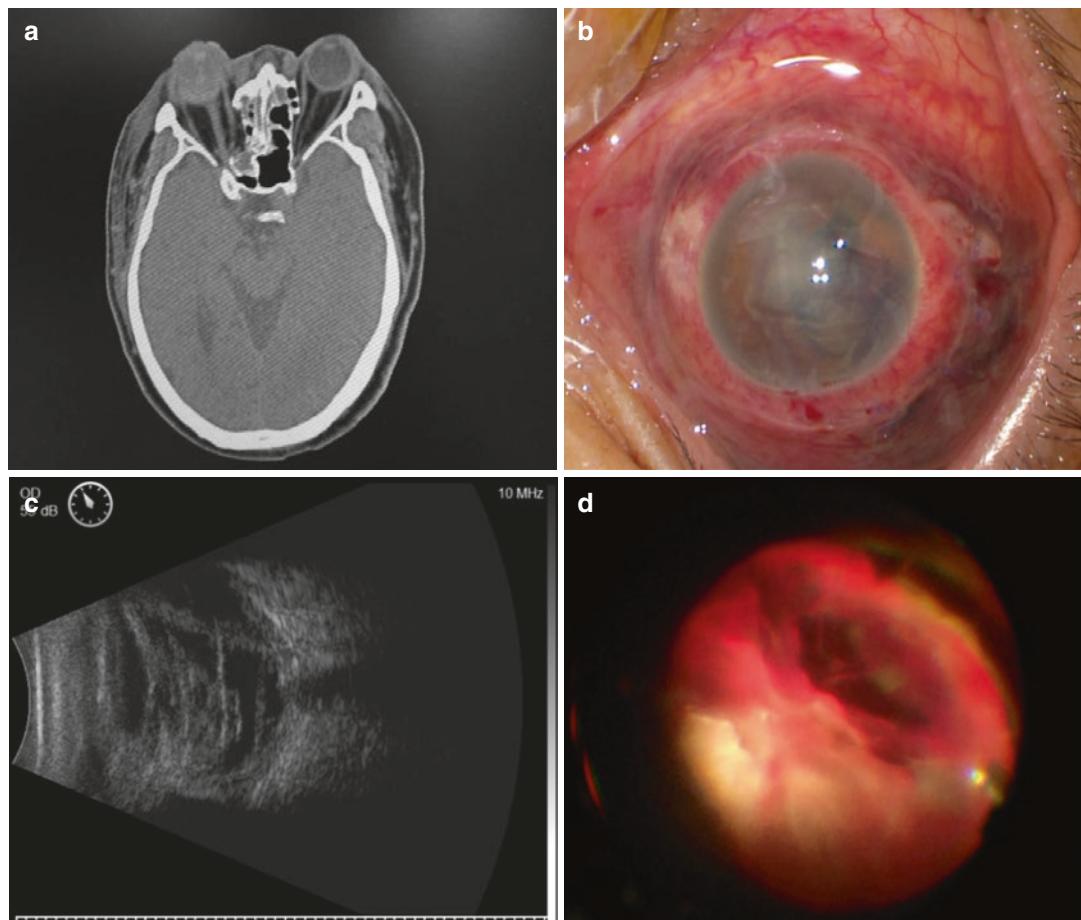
Photographs of the right eye. (a) Computed tomography showed multiple fractures of the orbit, subarachnoid hemorrhage, optic nerve injury, and ruptured eye. (b) Anterior segment photography showed cornea
